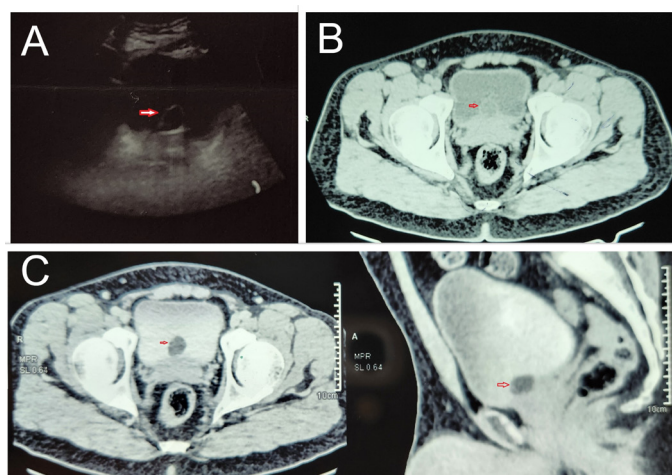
A. Ultrasound image showing a small cystic lesion (arrow) in the bladder neck region above the prostate. B. Midline cystic lesion measuring 1.9*1.8*1.3 cm at the level of the urinary bladder neck on plain computed tomography (CT). C. Contrast-enhanced CT showing bladder neck cyst as a filling defect, without any evidence of a solid-enhancing component or calcification
